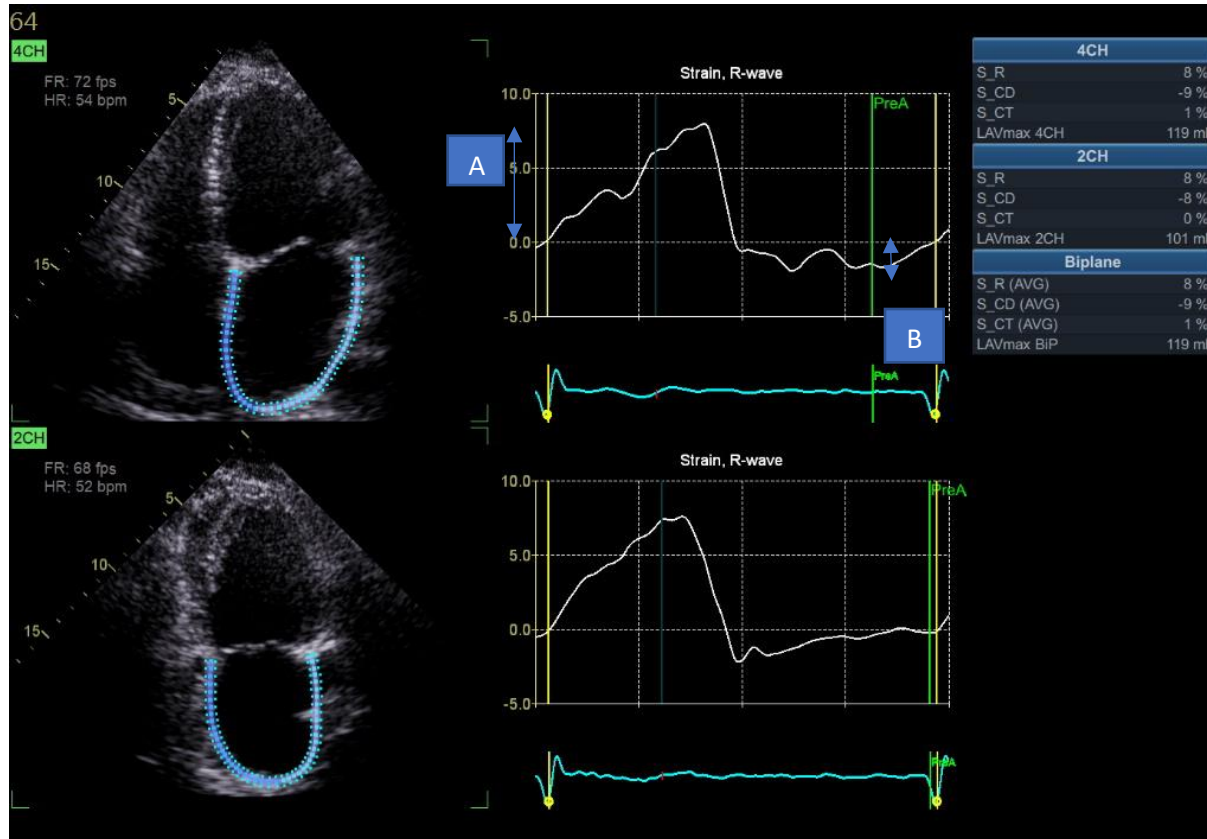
showing on 1) Left panel: Tracking of the LA endocardium in apical 4 chamber and apical 2 chamber and 2) Right hand panel: Using QRS as reference point, tracking of the LA endocardium movement throughout LA filling, diastasis and contraction allows the calculation of corresponding LA reservoir, conduit and contractile function. LA phasic results in biplane mode were used for this study.
